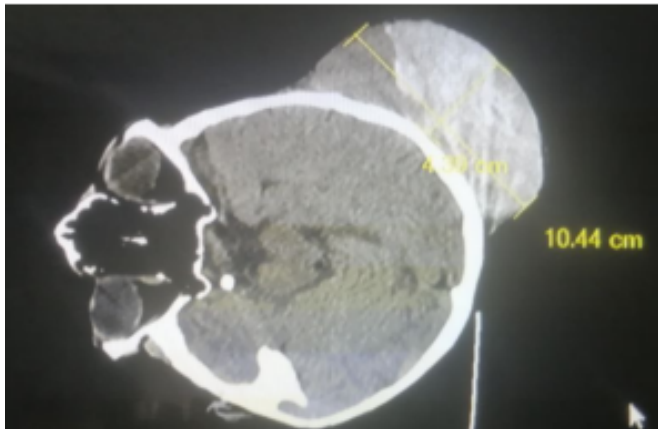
Initial brain CT scan showed huge subgaleal hematoma
